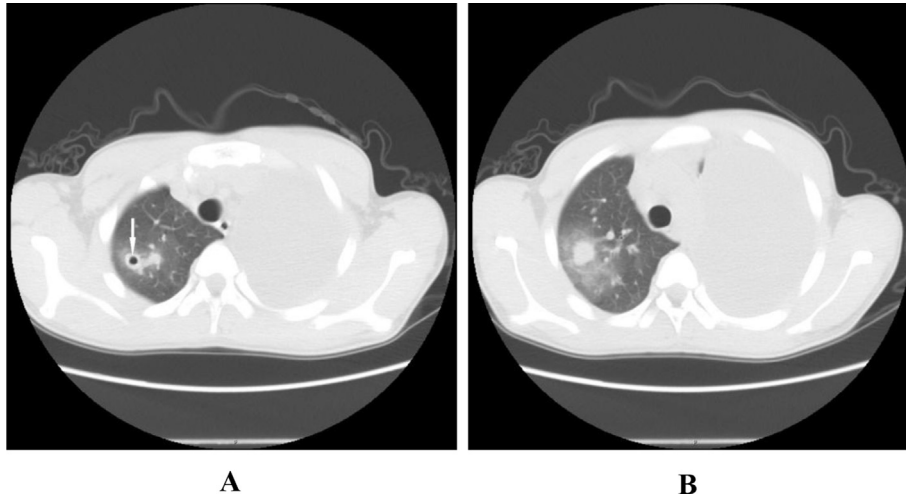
A 16-year-old boy with pulmonary paragonimiasis. Plain CT scan of chest shows worm cyst within the nodule (arrow) (A), and ground glass opacity surrounding the nodule (halo sign) in right upper lobe (B). Atelectasis of left lung due to massive pleural effusion can be seen.
